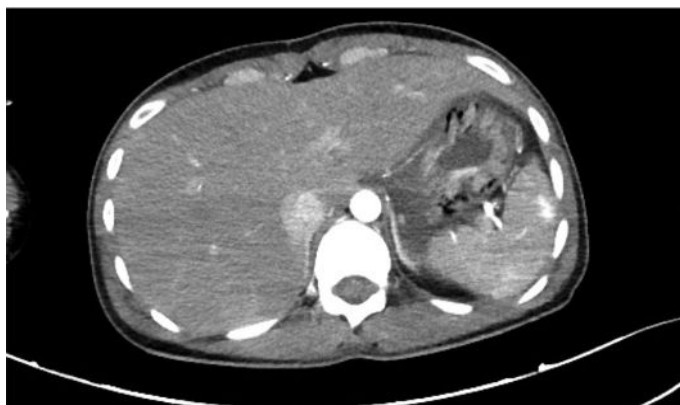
CT scan showing air in the stomach wall
